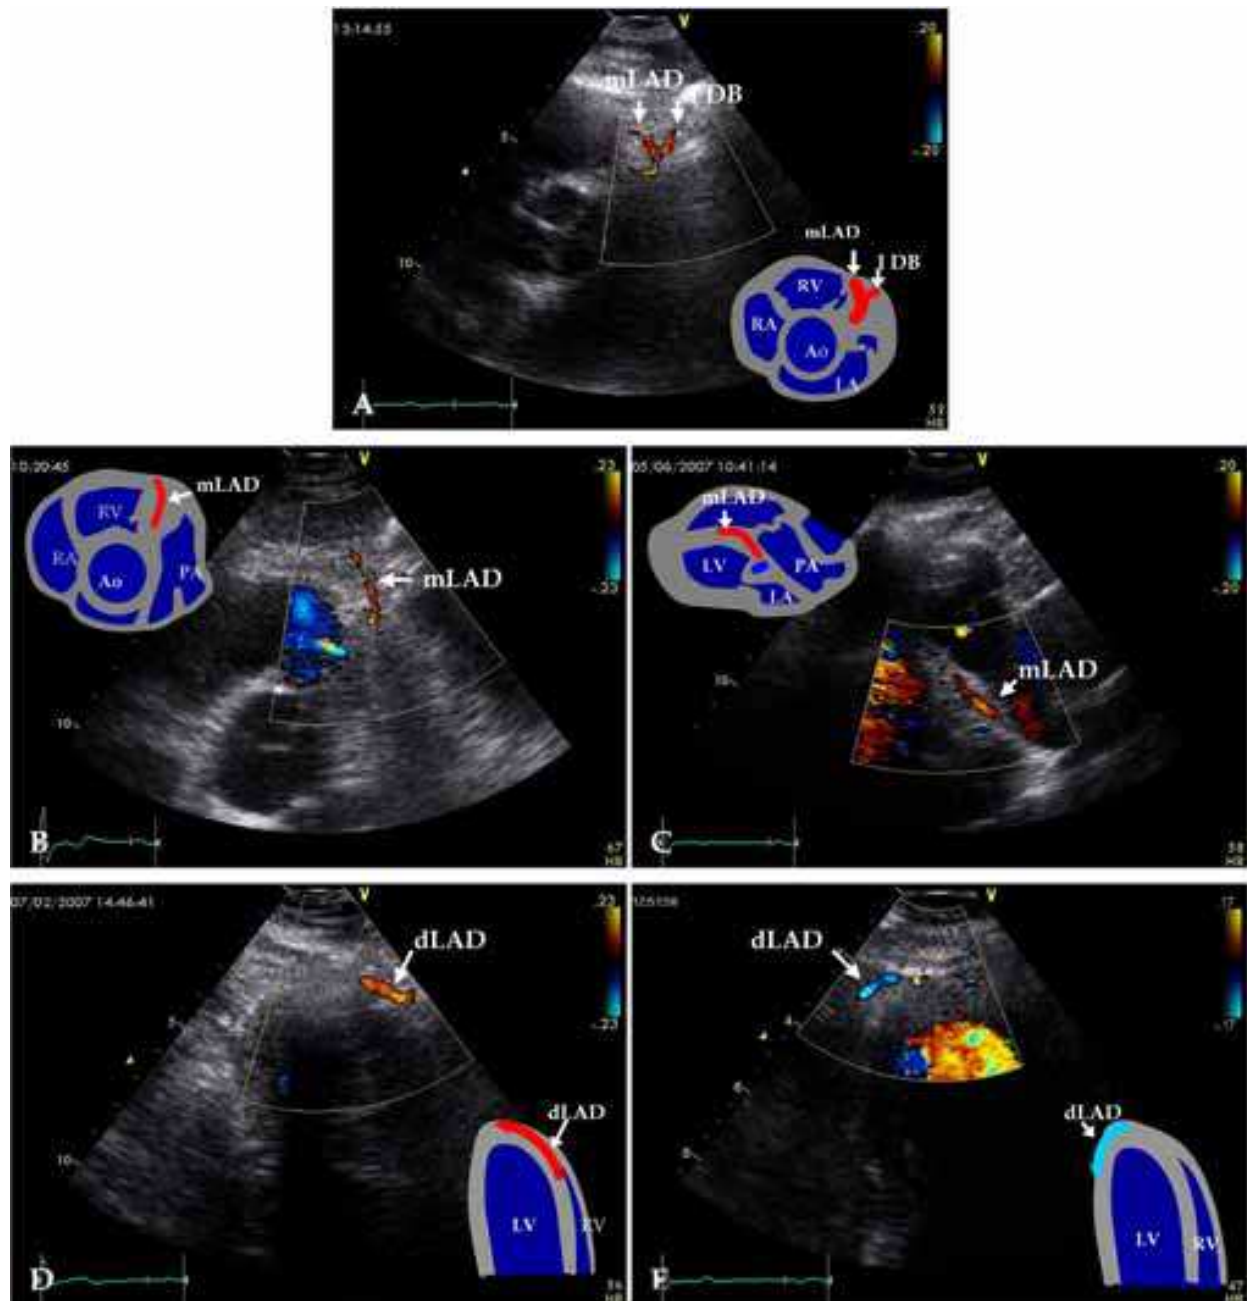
Doppler Color images of the LAD. A - distal board of proximal LAD with origin of the first diagonal branch (I DB); B - mid LAD (mLAD), the left parasternal position, a modified parasternal short axis view of great vessels; C - mLAD, the left parasternal position, a modified parasternal long axis view; D - distal LAD (dLAD) before circumflexing the cardiac apex, a modified apical five chamber position; E - dLAD after circumflexing the apex of the left ventricle.
